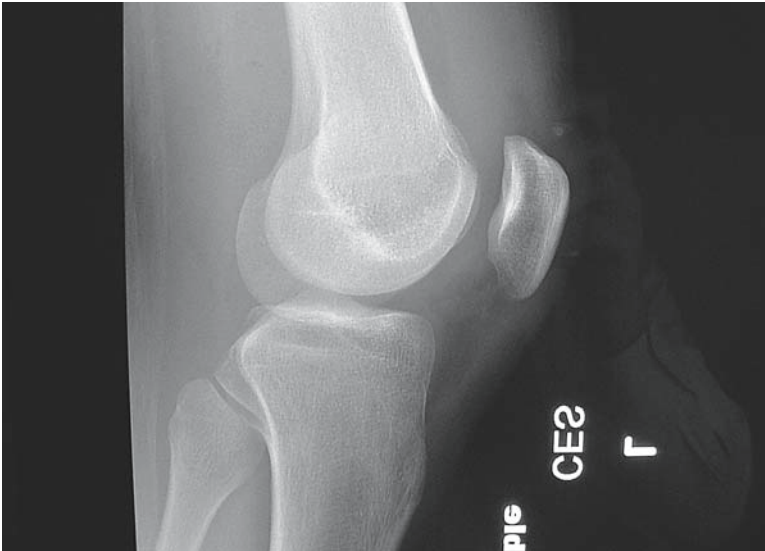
Lateral radiograph of the knee. An effusion is evident.
